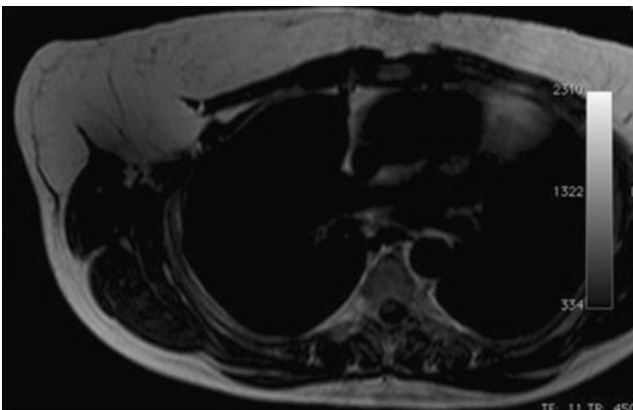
MRI scan showing lipomatous tumour
